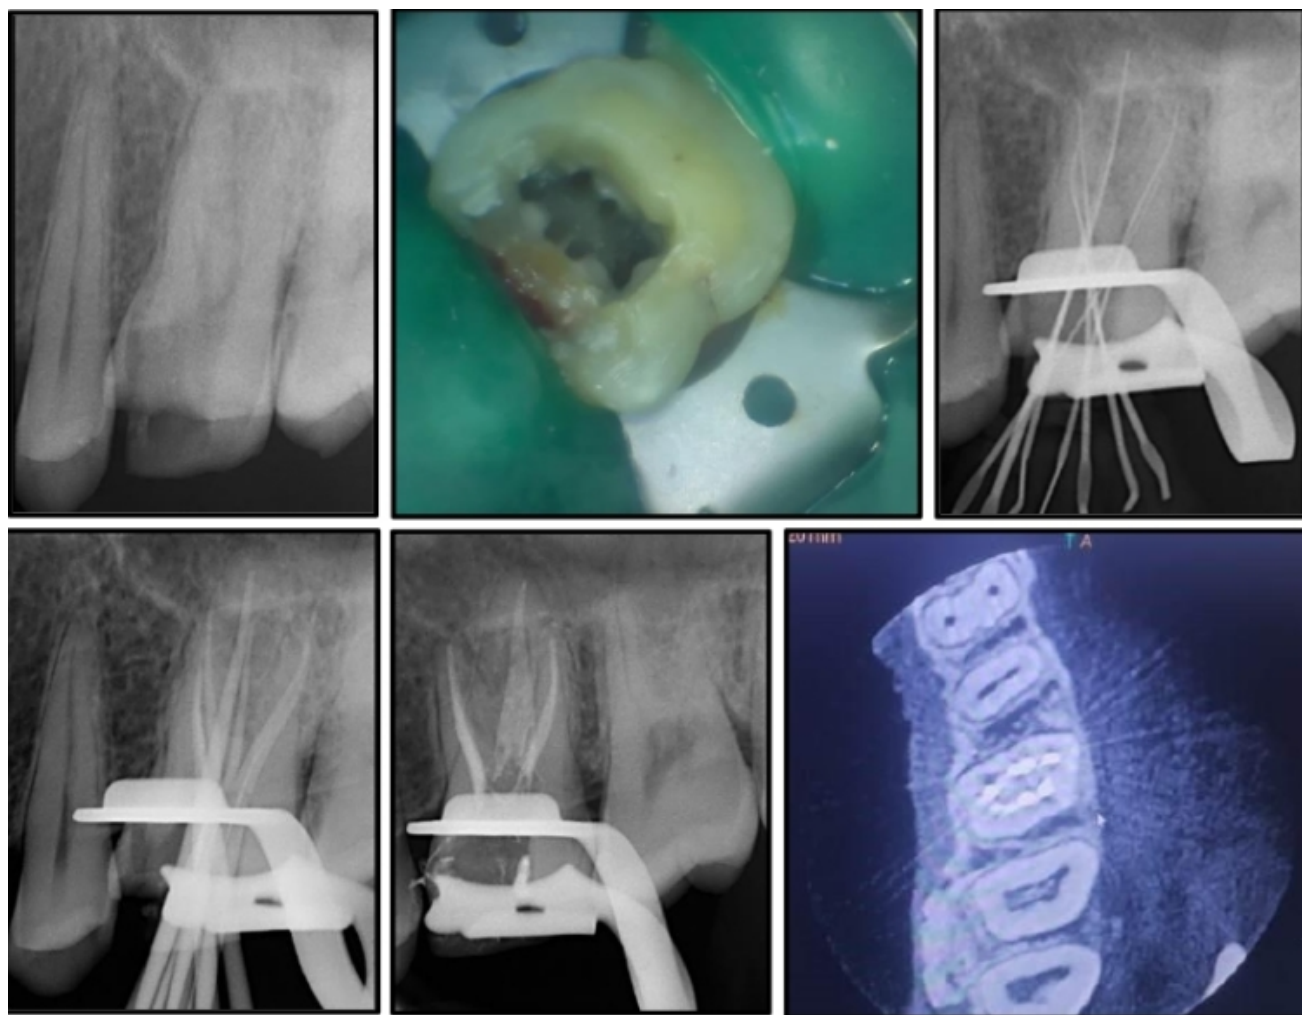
A: Preoperative radiograph; B: Access opening photograph; C: Working length radiograph; D: Master cone radiograph; E: Obturation radiograph; F: Post obturation photograph; G: Post obturation CBCT image shows seven obturated root canal orifices in the maxillary first molar.
